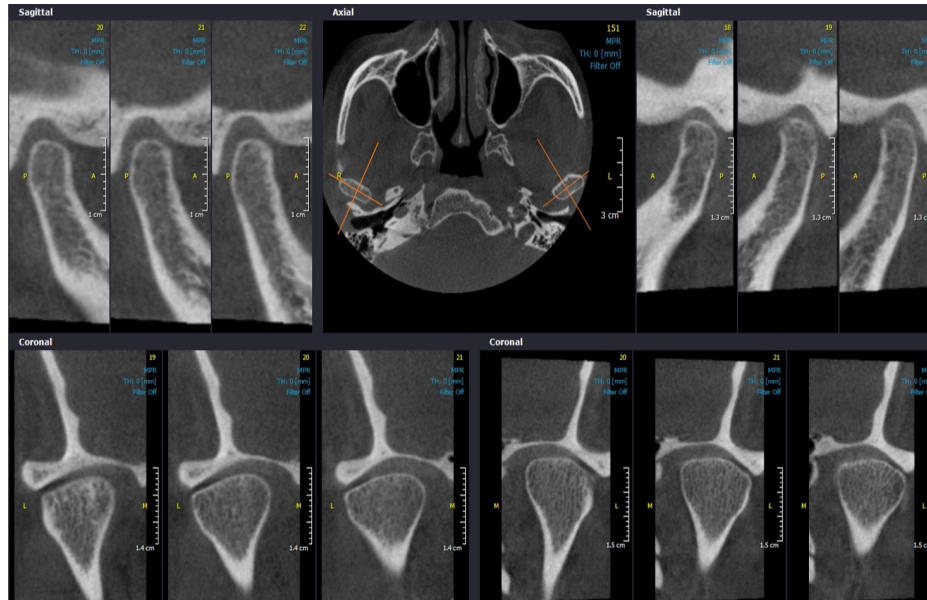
CBCT Corrected Sagittal and Coronal views of the right and left TMJs shows Flattening, Sclerosis and Surface erosion on the left condyle.
